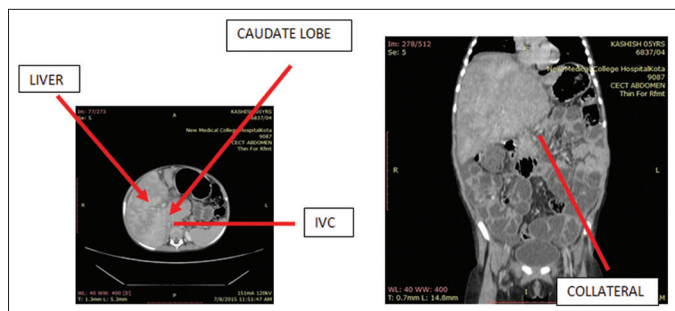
Contrast enhanced CT scan of abdomen showing hepatomegaly with enlarged caudate lobe and veno-venal collaterals
